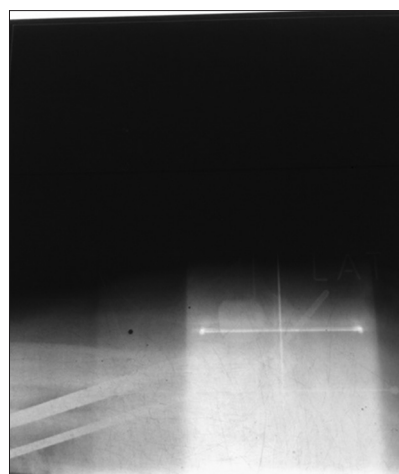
Lateral X-ray of pelvis
